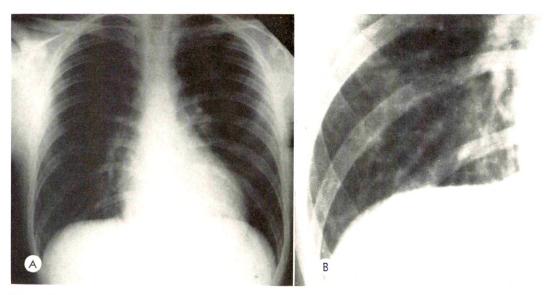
Chest roentgenogram at the age of 14 (A) showing apparently normal heart and lungs. The patient did not present any pulmonary symptoms. A close-up view of the right lower lung field (B) shows a fine increase in the pulmonary markings representing interlobular septa.
